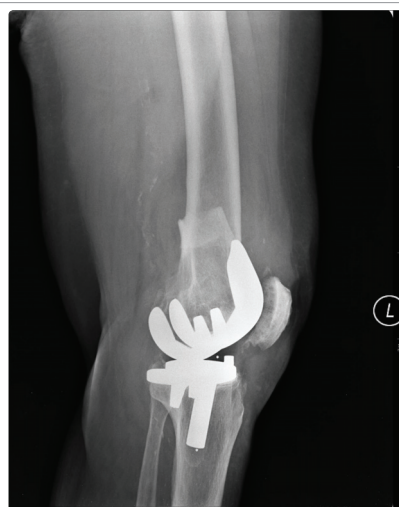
X-rays of the patient demonstrating a Rorabeck type 2 supracondylar displaced periprosthetic fracture
